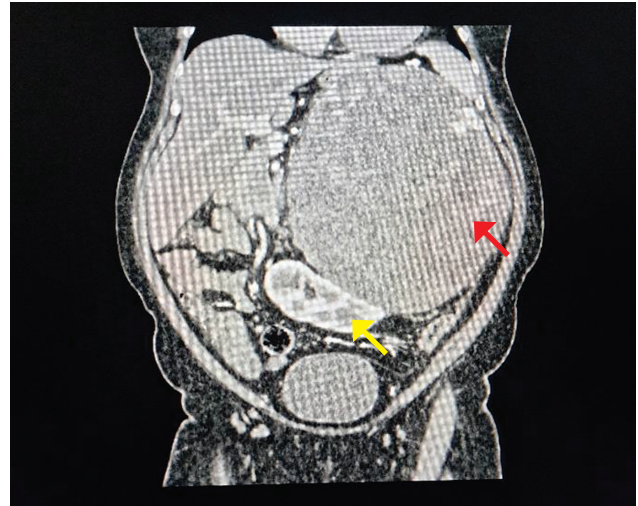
CT scan of the abdomen showing a large heterogeneously-enhancing mass (red arrow), displacing the left kidney (yellow arrow) caudally and medially.
